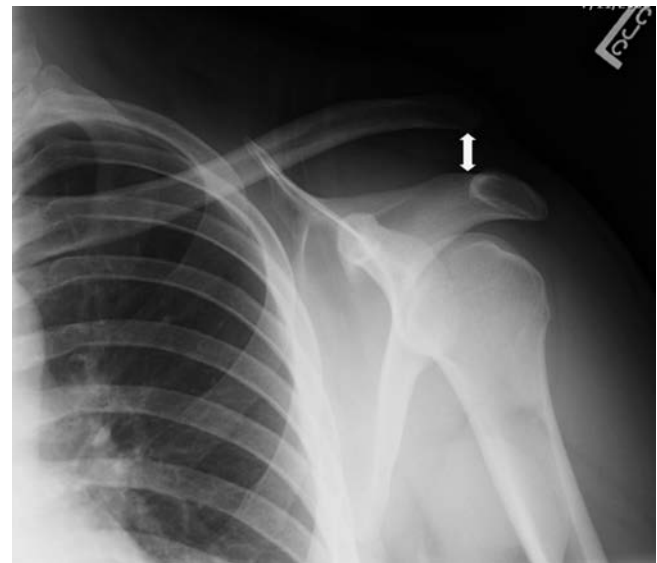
AC separation is commonly referred to as a “separated shoulder” and can be classified as grade 1 (AC ligament and coracoclavicular [CC] ligaments intact, radiographically normal), grade 2 (AC ligament disrupted, CC ligament intact), or grade 3 (both ligaments disrupted, resulting in a separation of the acromion and clavicle greater than half the width of the clavicle).
